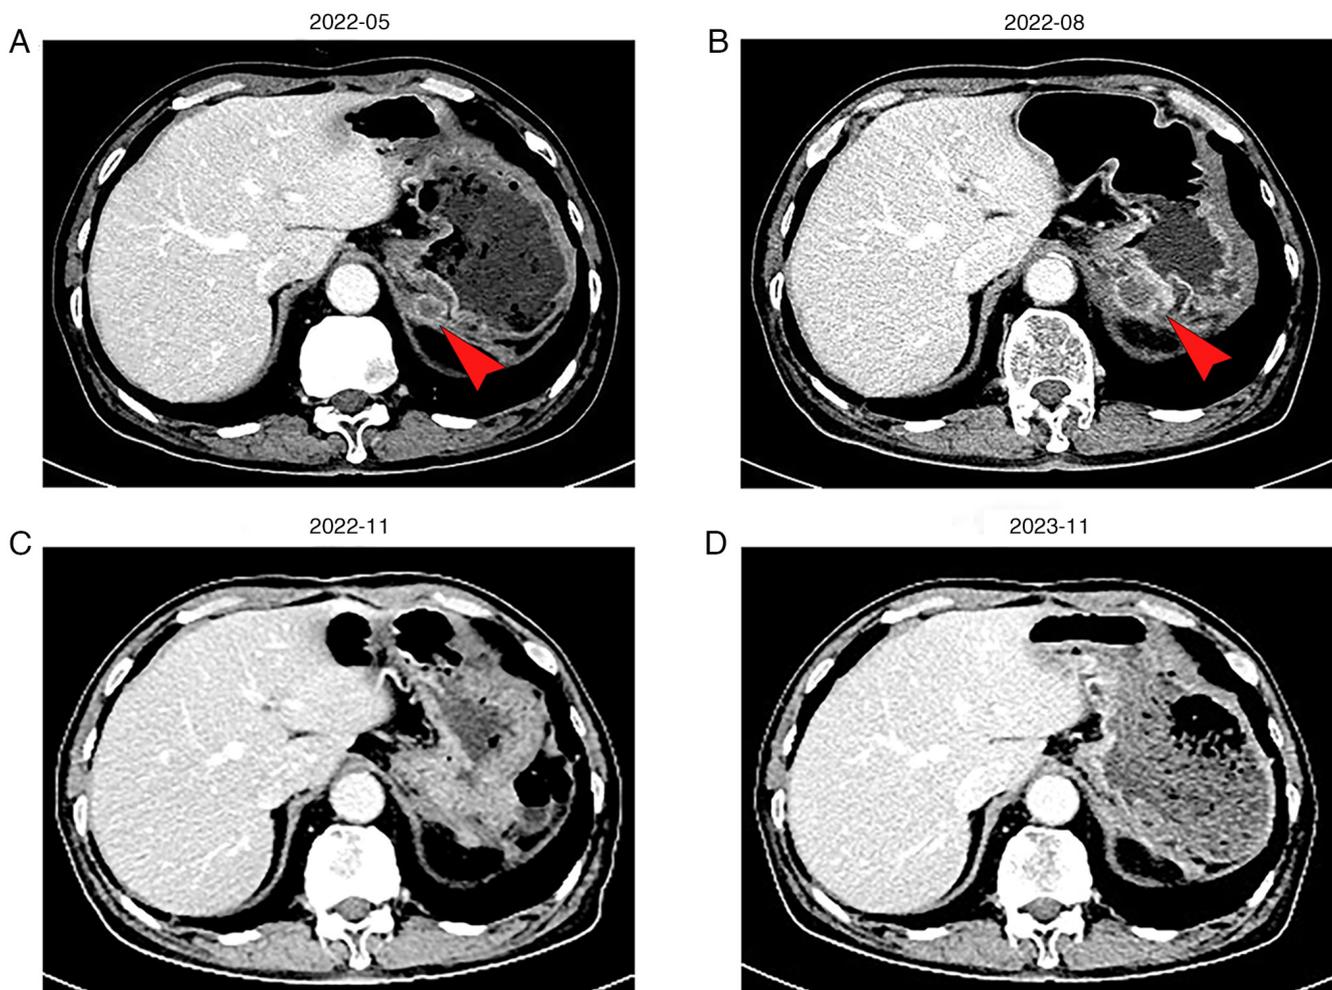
CT scan images following recurring metastasis, the red arrow denotes the posterior cardiac lesion location. (A) The initial recurrent CT examination showed a mass behind the cardia, ~1.7x1.3 cm. (B) On follow-up for 3 months, the posterior cardia mass was enlarged compared with the previous one, about 2.3x2.8 cm. (C) After four cycles of combination therapy, the lesion in the posterior cardia had disappeared. (D) After 20 cycles of this combination therapy, no tumor relapse was observed. CT, computed tomography.
